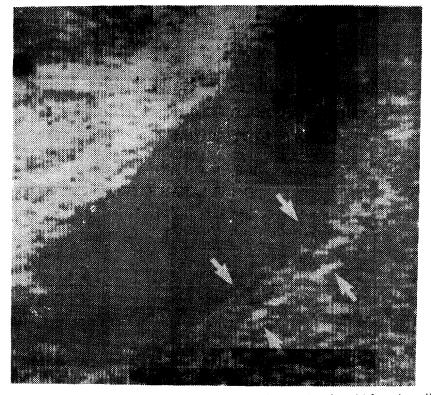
(A) Ultrasound shows two hypoechoic layers in the thickened walls of gall bladder (between arrows).
